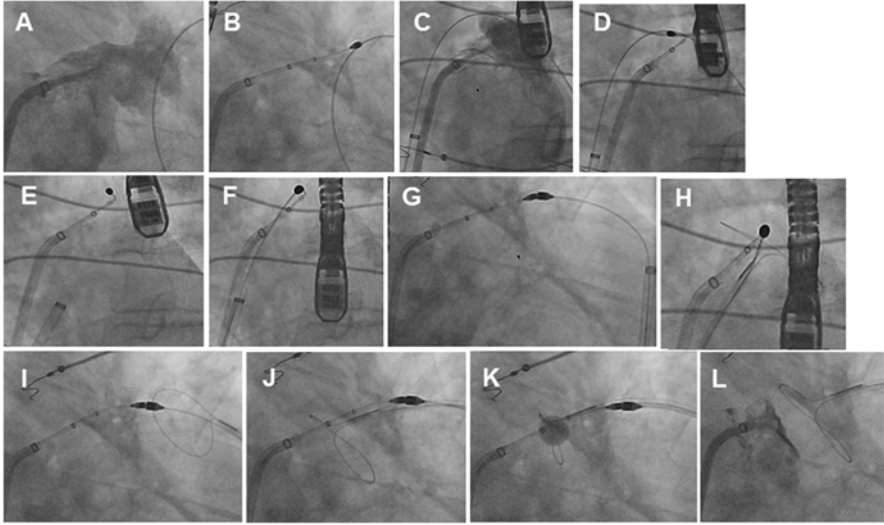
Overview of LAA ligation with the LARIAT device. Percutaneous LAA ligation with the LARIAT suture delivery device requires an anterior pericardial access and a transeptal puncture. After transeptal puncture, a LA angiogram is performed in the RAO caudal (panel a) and LAO (panel c) fluoroscopic views to allow placement of the endocardial magnet-tipped guidewire into the most anterior lobe of the LAA (panels b and d). Connection of the epicardial magnet-tipped guidewire to the endocardial magnet is facilitated by rotating the epicardial sheath in the LAO view, so that the tip of the sheath is directed toward the endocardial magnet-tipped guidewire (panel e). Connection of the magnet-tipped guidewires should result in symmetrical alignment of the guidewires in both the LAO (panel f) and RAO caudal (panel g) fluoroscopic views. The LARIAT snare is then advanced over the epicardial magnet-tipped guidewire through the epicardial sheath. Alignment of the LARIAT snare is performed in the LAO fluoroscopic view to assure that the snare is positioned to move freely over the posterior aspect of the LAA (panel h). This should also result in the LARIAT snare being aligned in the RAO fluoroscopic view (panel i). Connection of the magnet-tipped guidewires stabilizes the LAA and allows positioning of the LARIAT suture delivery device over the LAA in an “over-the-wire” approach (panel j). Proper positioning of the snare over the LAA is guided by TEE-guided placement of the inflated balloon catheter at the mouth of the LAA and closure of the snare over the balloon (panel k). Confirmation of complete capture of the LAA is obtained with TEE and contrast LA angiography prior to release of the suture. If the snare closure does not result in complete capture of the entire LAA, the snare can be opened and repositioned to ensure complete LAA capture. Complete closure of the LAA is seen by the lack of color flow Doppler and LA angiography (L) (Reproduced from Koneru et al. [14] with permission)
